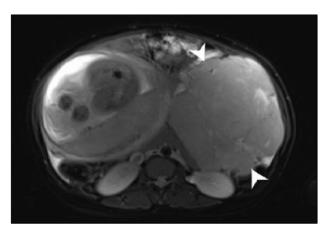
Transverse MRI view demonstrating the soft-tissue lesion in the left lumbar region (indicated by arrows). Abbreviation: MRI.
